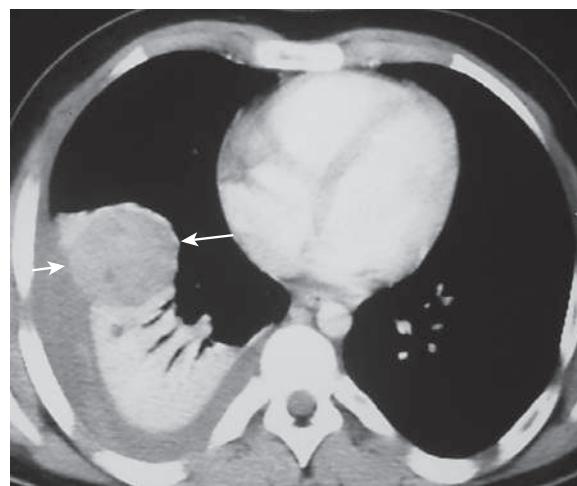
Inflammatory myofibroblastic tumor. An afebrile 13-yr-old male who presented with increasing dyspnea and right-sided pleuritic chest pain. Axial contrast-enhanced CT of the chest shows a rounded heterogeneously enhancing lesion (arrows) located adjacent to an area of atelectatic lung. Pleural fluid at the same level demonstrates increased attenuation consistent with a hemithorax. (Modified from Chu WCW, Epelman M, Lee EY. Neoplasia. In Coley BD, ed. *Caffey's Pediatric Diagnostic Imaging*, 13th ed. Philadelphia: Elsevier; 2019: Fig. 55.8A, p. 531.)
